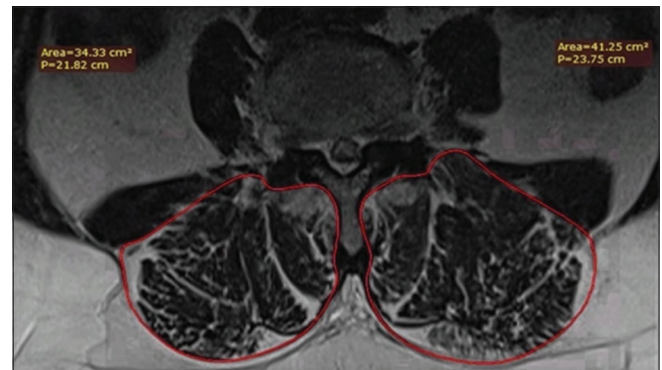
Total cross-sectional area measurements on axial magnetic resonance images
